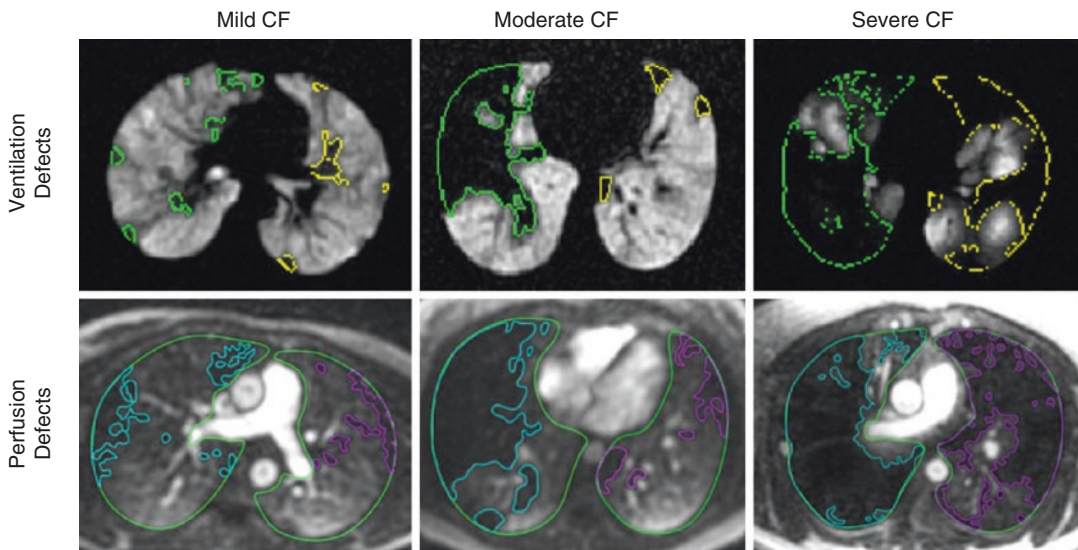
Ventilation defects observed with hyperpolarized gas MRI (*top row*) are well matched to perfusion defects observed with dynamic contrast-enhanced perfusion MRI
